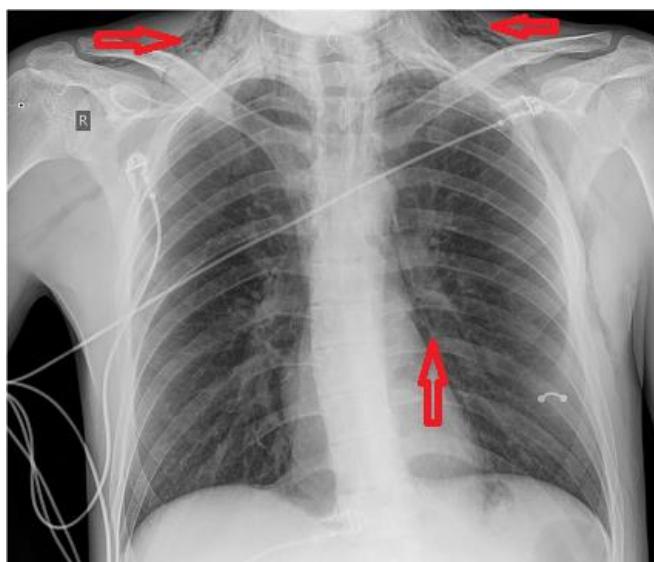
Chest X-Ray – extensive subcutaneous emphysema and pneumomediastinum. No pneumothorax.
